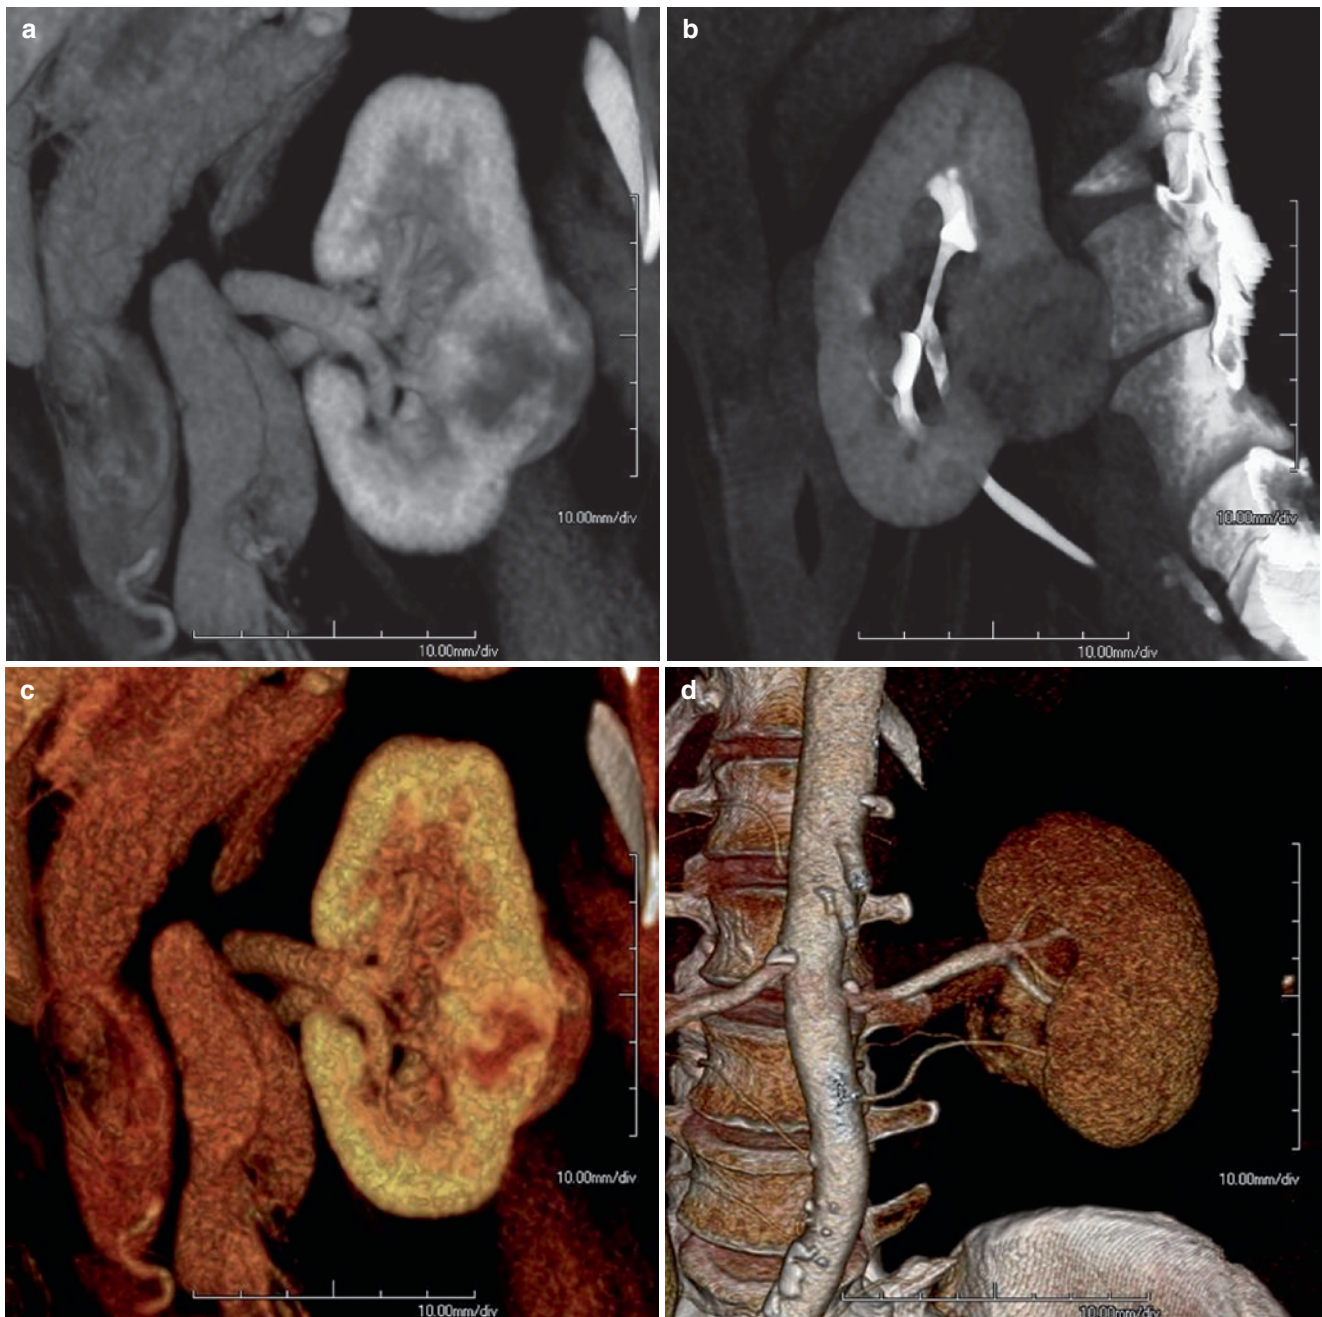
3D CT scan image demonstrating a 4x4.3cm hypervascular interpolary left renal mass. There are two left renal arteries, including a lower polar artery. (Image courtesy of Christoph Wald, Lahey Clinic)
